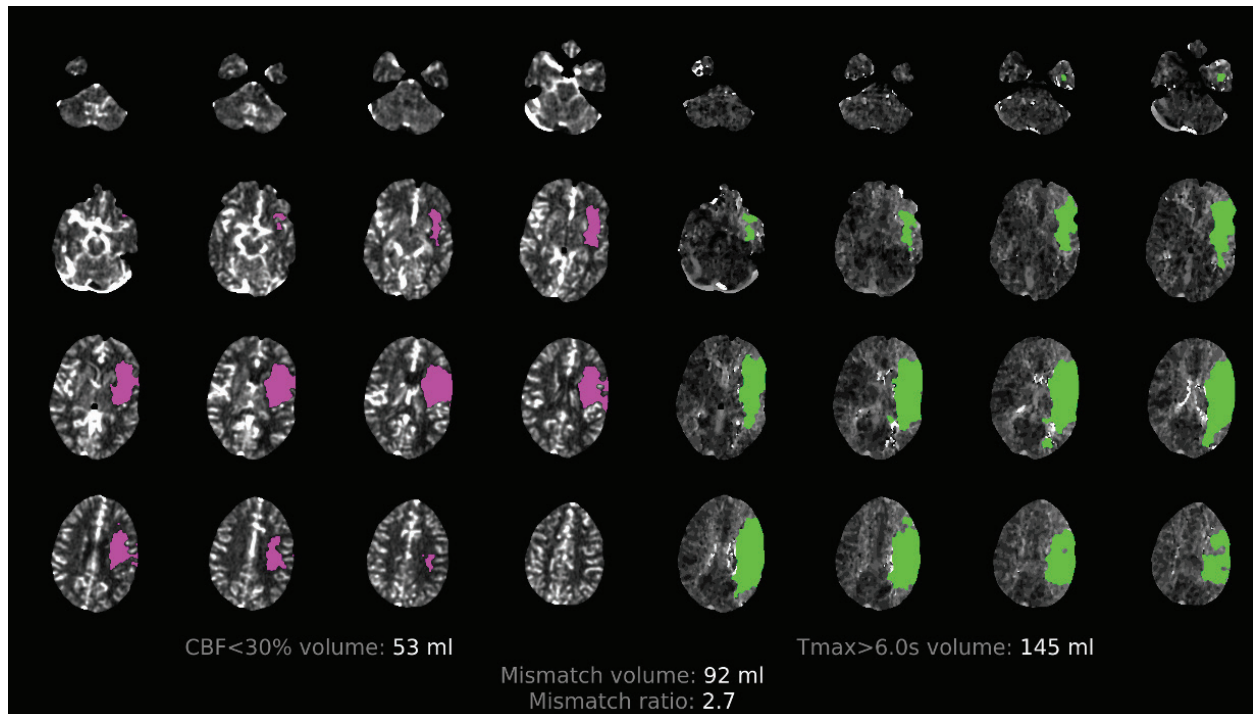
CT perfusion scan processed with artificial intelligence software showing a core infarct volume of 53 mL (correlating with the areas of early infarct noted on CT [Figure 1]) with significant ischemic penumbra measuring approximately 145 mL and a mismatch volume of 92 mL, the latter representing the volume of salvageable tissue with a mismatch ratio greater than the threshold for treatment of 1.8.
